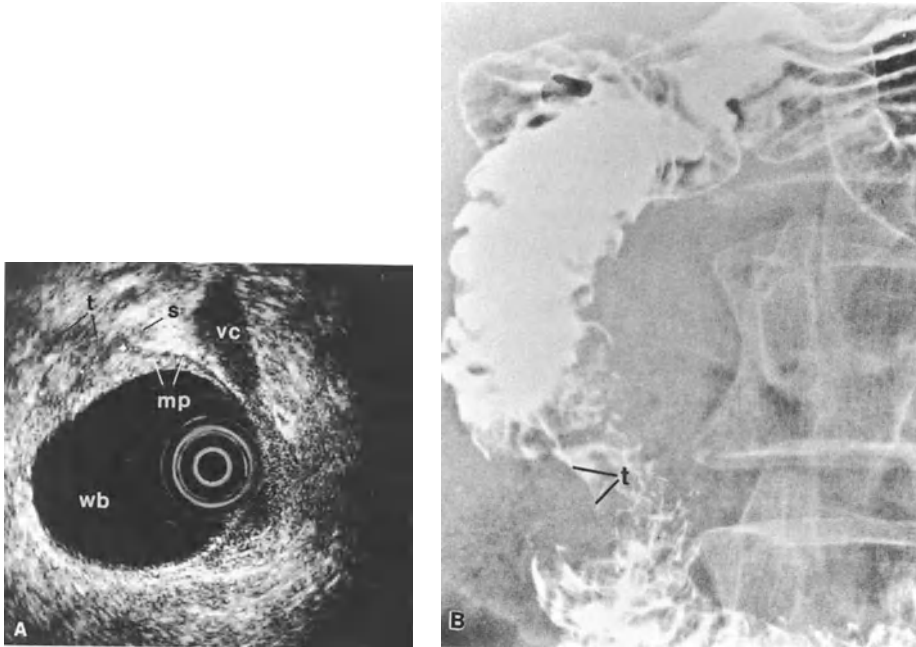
A Endoscopic sonogram showing a clearly demarcated hypoechoic tumor (*t*) penetrating through the muscularis propria (*mp*) into the serosal layer (*s*) adjacent to the vena cava (*vc*). *wb*, water-filled balloon. B Corresponding radiogram, revealing a filling defect (*t*) on the lateral side of the descending duodenum
